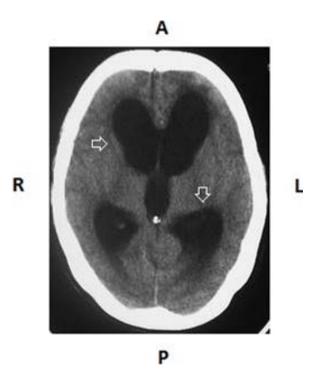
CT image of the NPH patient before insertion of a VP Shunt. Arrows indicate ventricular distention and periventricular edema is apparent. A: anterior, P: posterior, L: left, R: right.
